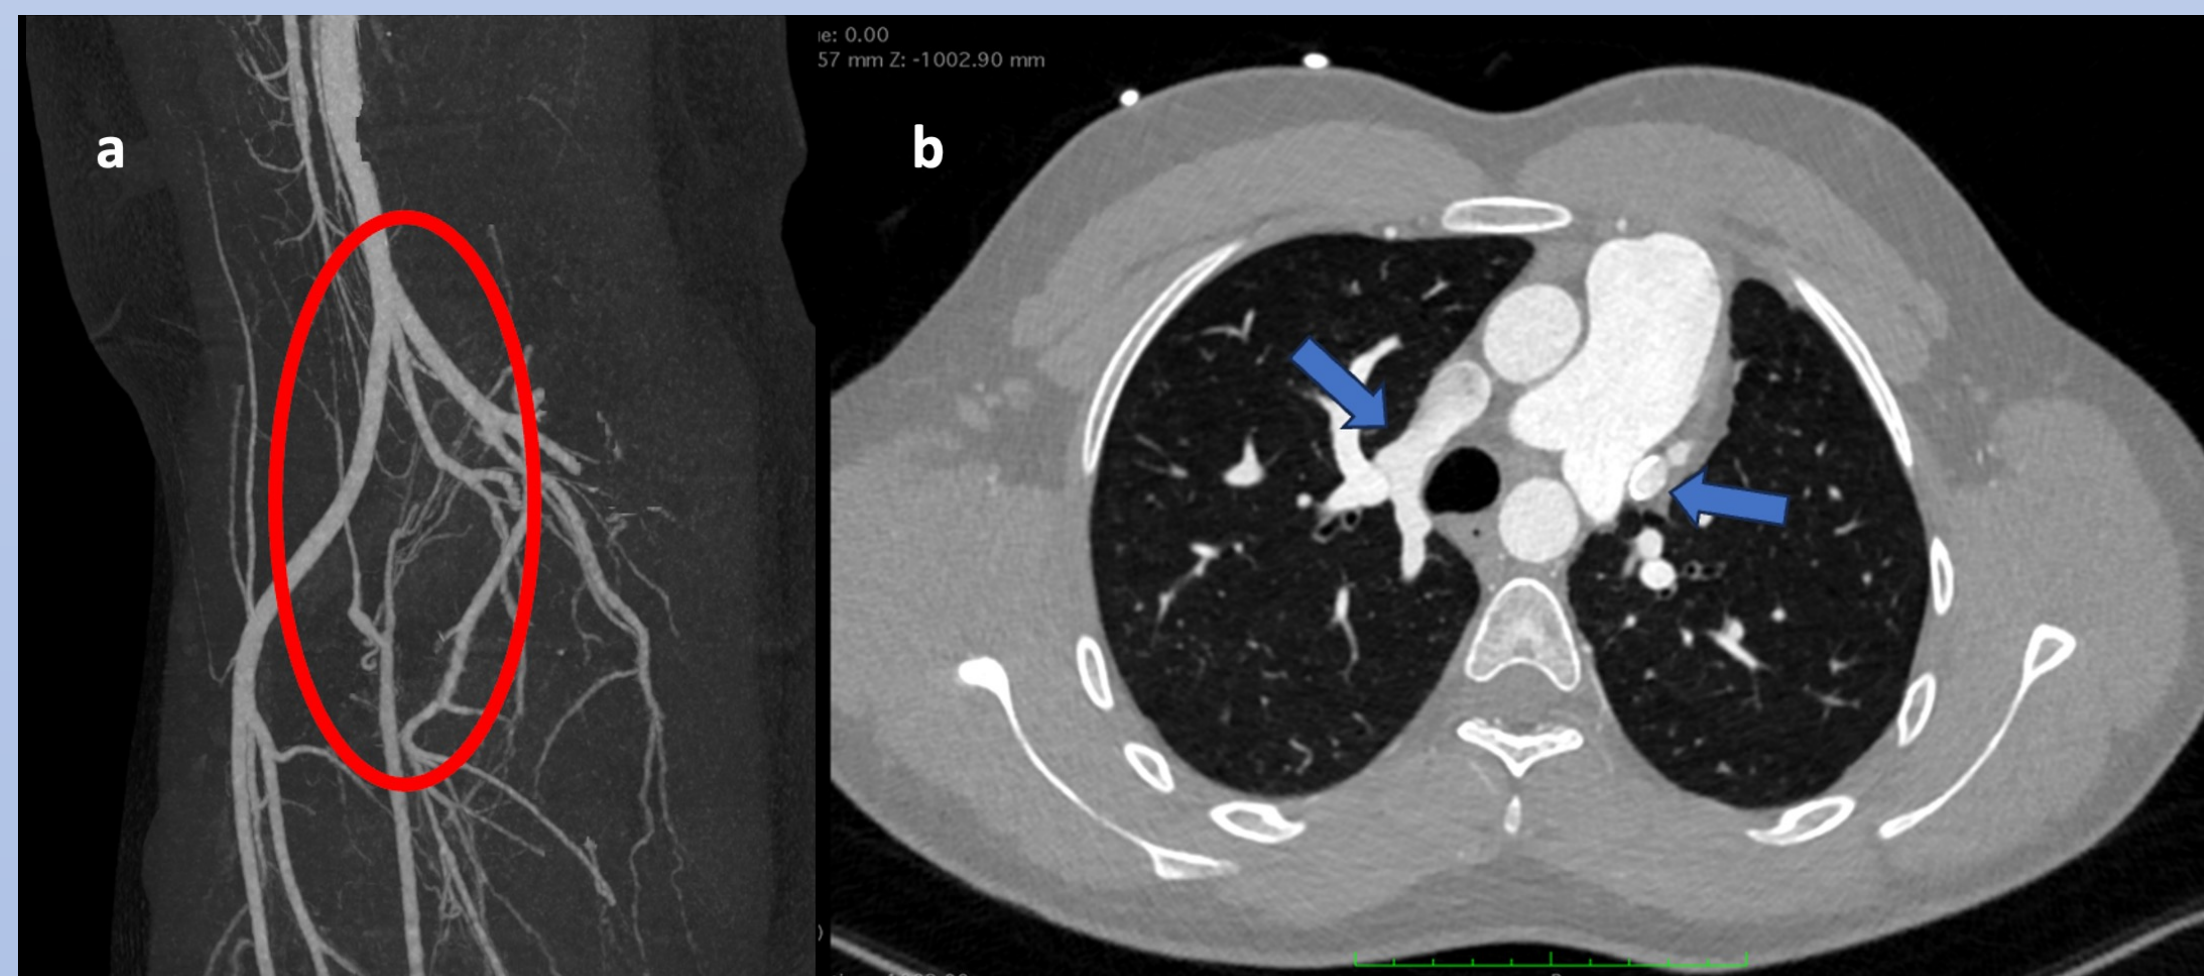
Reconstructed CTA image of the iliac arteries (a) and CTA image showing the persistent left superior vena cava and right upper pulmonary vein draining into right superior vena cava (b).
